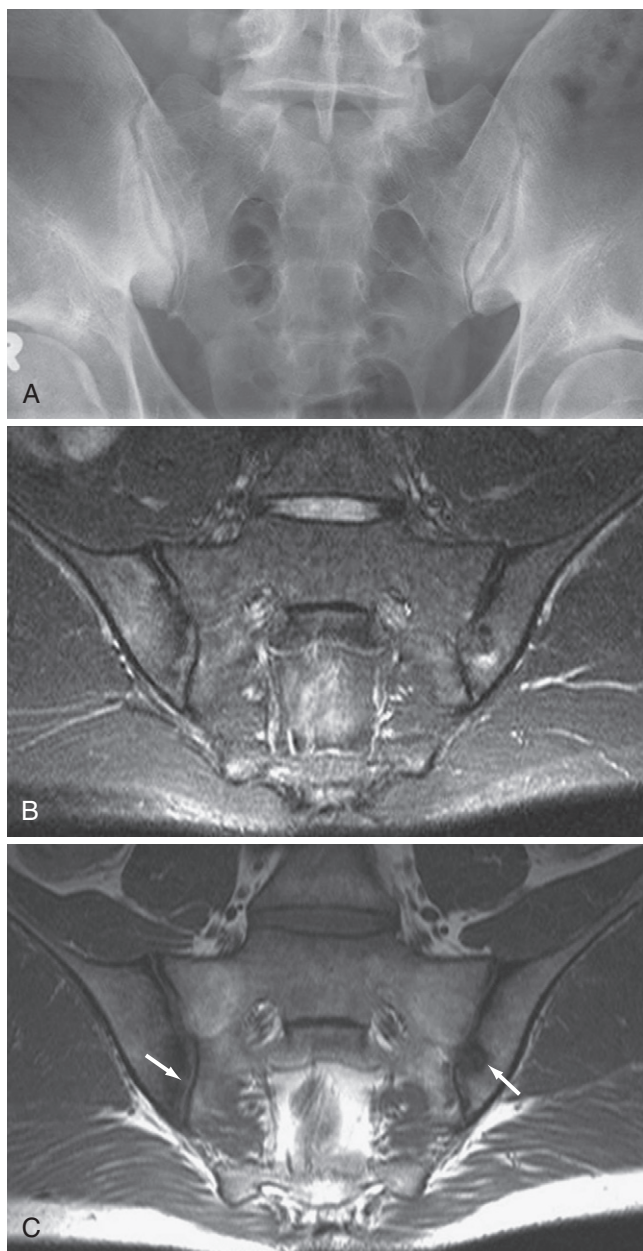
Inflammatory back pain (x-ray and magnetic resonance imaging [MRI]). A 31-year-old man with inflammatory back pain. A, X-ray of the sacroiliac joints demonstrates only very subtle findings with possible sclerosis on the iliac side of the right sacroiliac joint and subtle spur formation at the inferior margin. B and C, MRI at the same time shows obvious findings of spondyloarthritis with mild bilateral iliac inflammation on short tau inversion recovery (B) and multiple findings on T1-weighted images (C), including sclerosis most prominent on the right side and subchondral erosion (arrows), which are very small on the right side and obvious on the left side.
